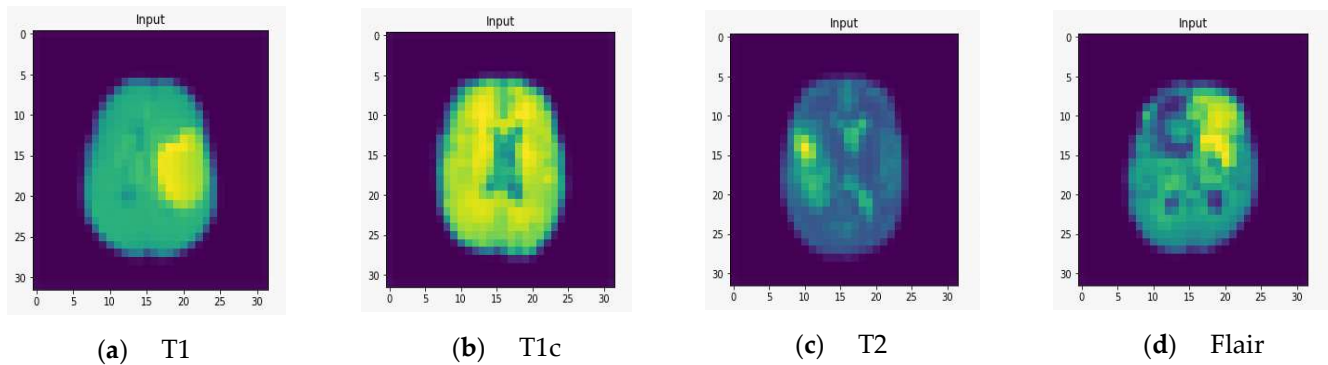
Rendering of T1, T1c, T2, and FLAIR at a resolution of $32 \times 32 \times 32$.
